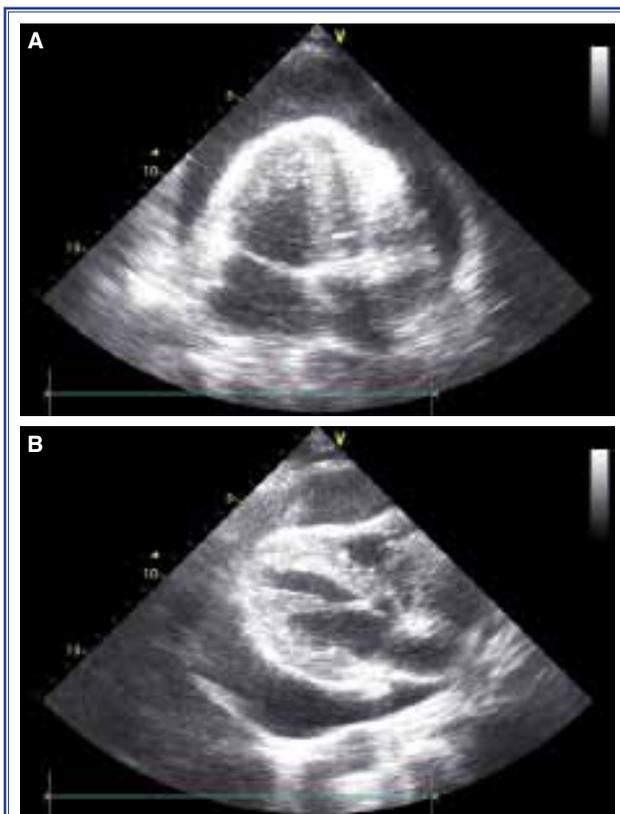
(A) Massive pericardial effusion in apical four-chamber view. (B) Massive pericardial effusion in parasternal long-axis view.
